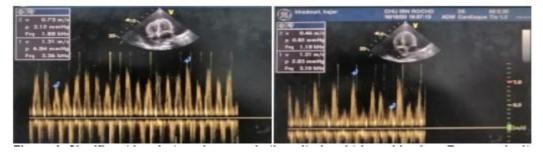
Significant inspiratory decrease in the mitral and tricuspid valves E wave velocity on pulse wave Doppler tracing
